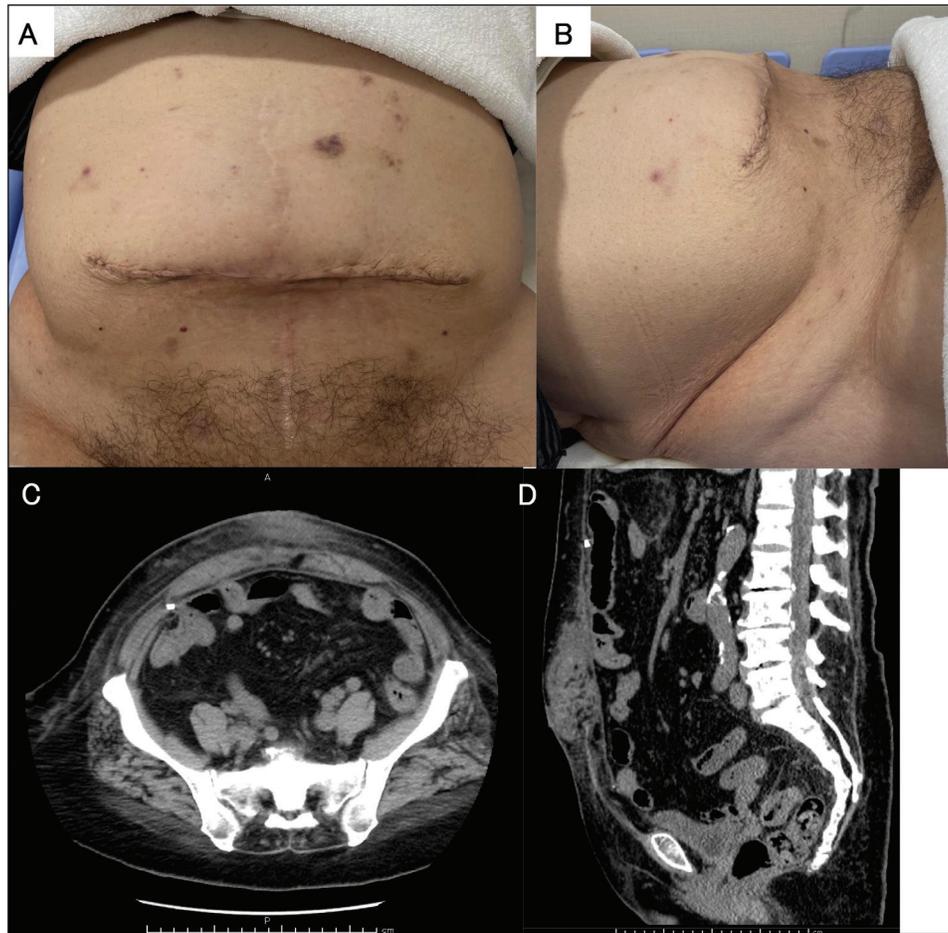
Postoperative findings 3 months after surgery. (A and B) Wound findings. (C and D) Abdominal computed tomography revealing no hernia prolapse or mesh bulging
